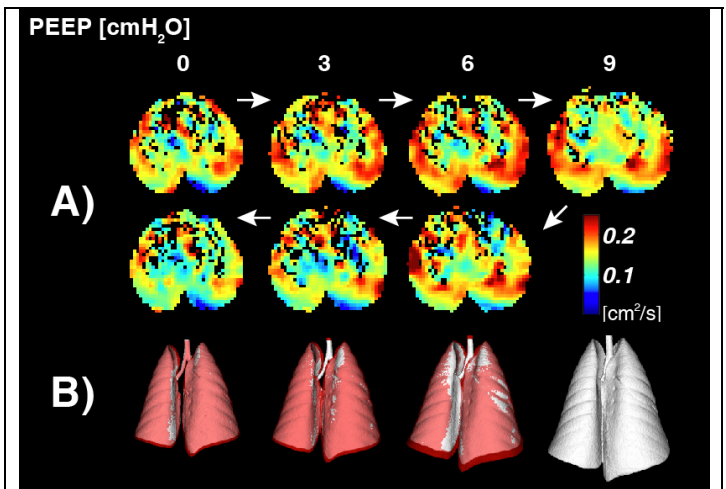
Representative MRI and CT images obtained during trials of ascending and descending PEEP: (A) ADC maps; (B) three-dimensional CT reconstructions (white: ascending PEEP, red: descending PEEP).
